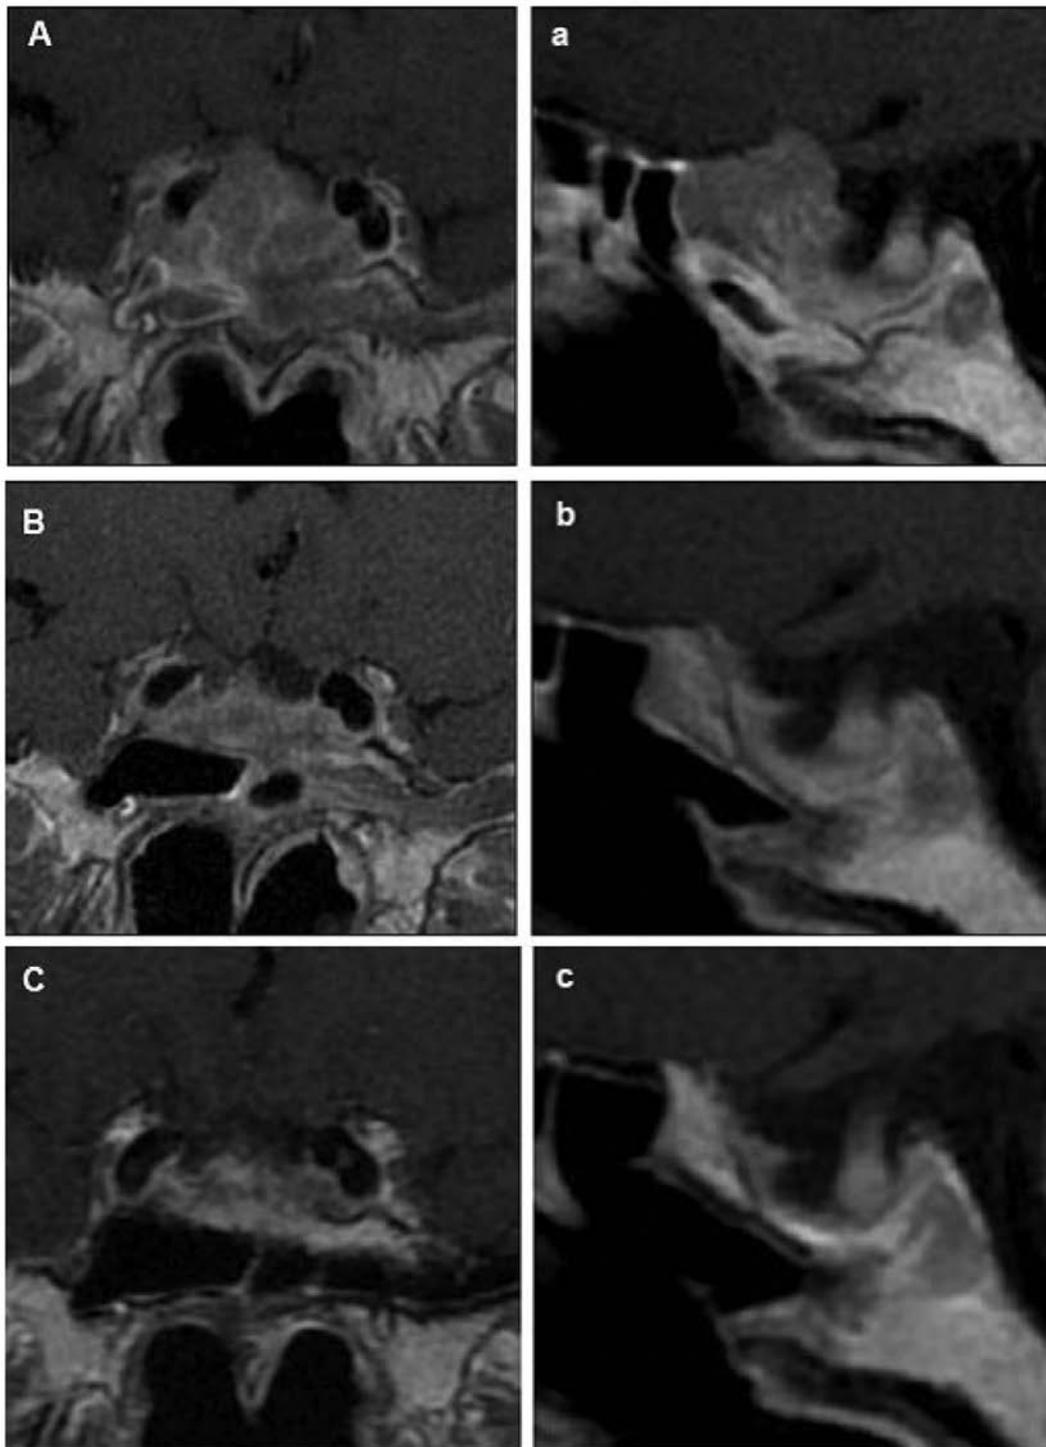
Coronal and sagittal MRI of the pituitary gland. [A/a] — regrowth of the tumour after third surgery, before TMZ treatment, [B/b] — after 6 courses of TMZ. [C/c] —sustained pituitary adenoma shrinkage after TMZ discontinuation with residual tumour invading right cavernous sinus, signs of secondary “empty sella”, pituitary gland placed at the floor of the sella
